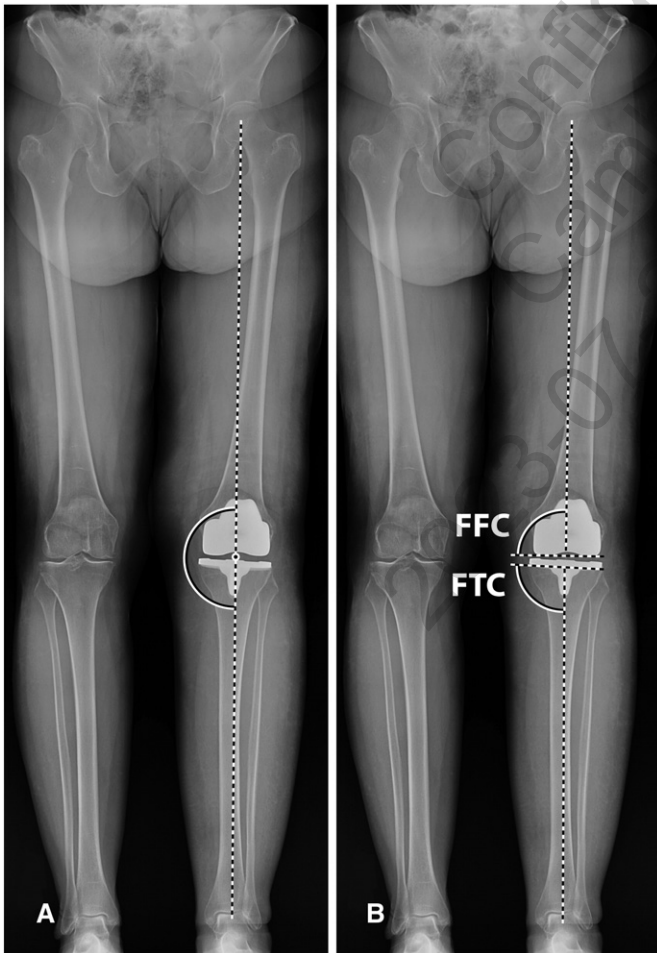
(A) Standing radiograph showing measurement of mechanical axis of the limb; (B) varus/valgus position of the femoral and tibial components was determined by measuring the femoral component (FFC) angle and frontal tibial component (FTC) angle relative to the mechanical axis on the long-leg radiographs.
